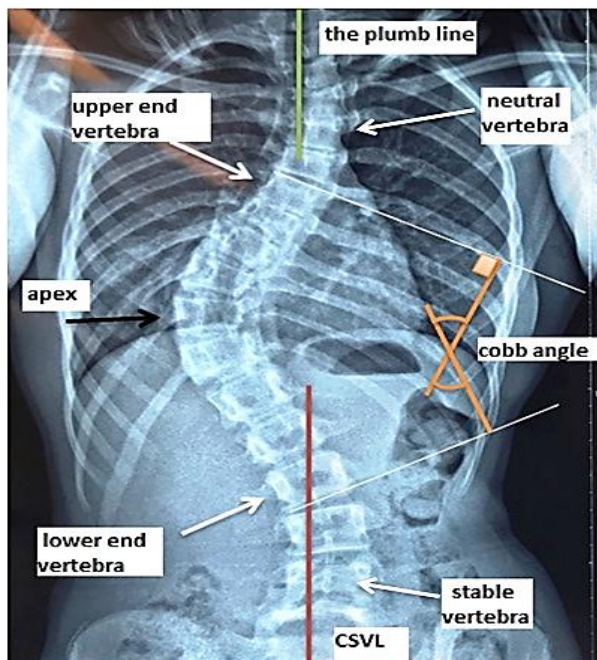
Whole spinal posteroanterior (PA) radiograph of a patient with adolescent idiopathic scoliosis (AIS)
